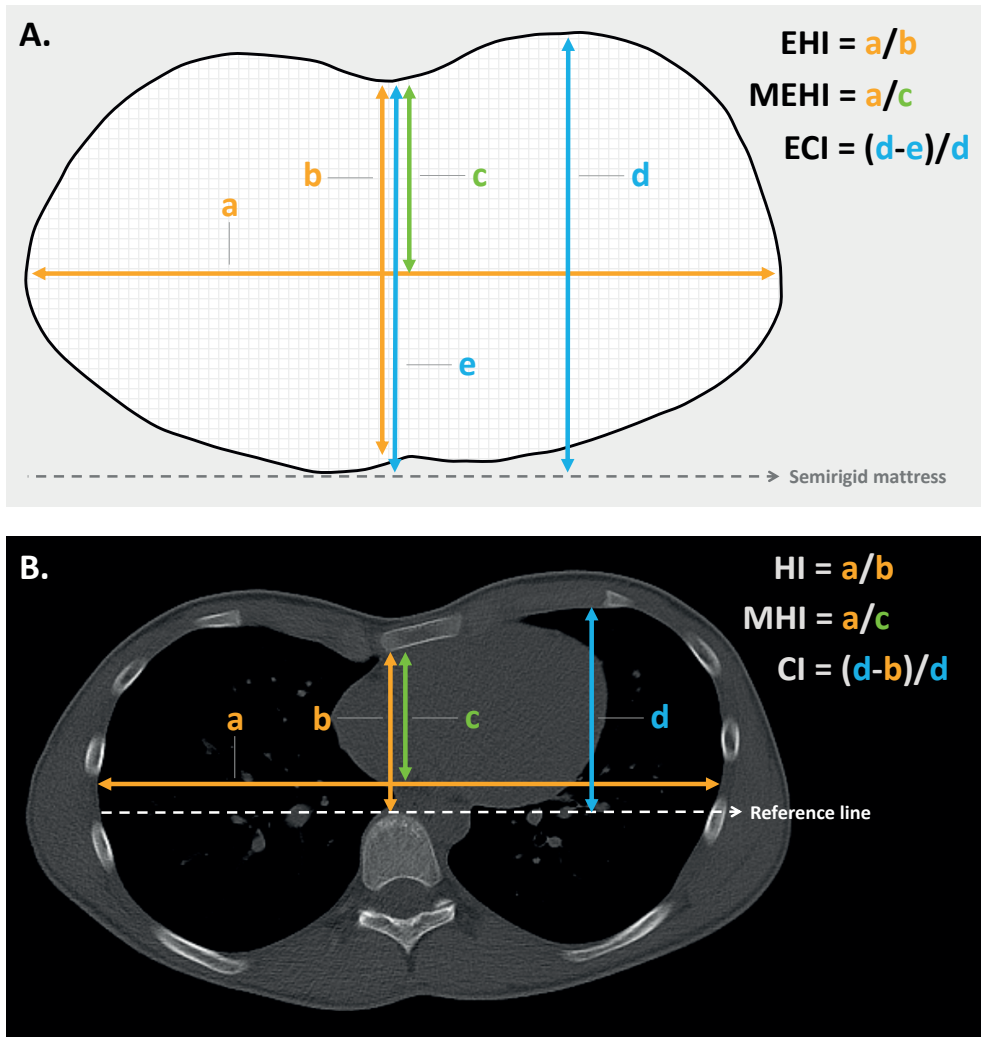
Pectus severity measurement methods. (A) Severity indices based on 3D surface scans; (B) severity indices based on CT-scans. *EHI*, external Haller index; *MEHI*, modified external Haller index; *ECI*, external correction index; *HI*, Haller index; *MHI*, modified Haller index; *CI*, correction index; *3D*, three-dimensional.
